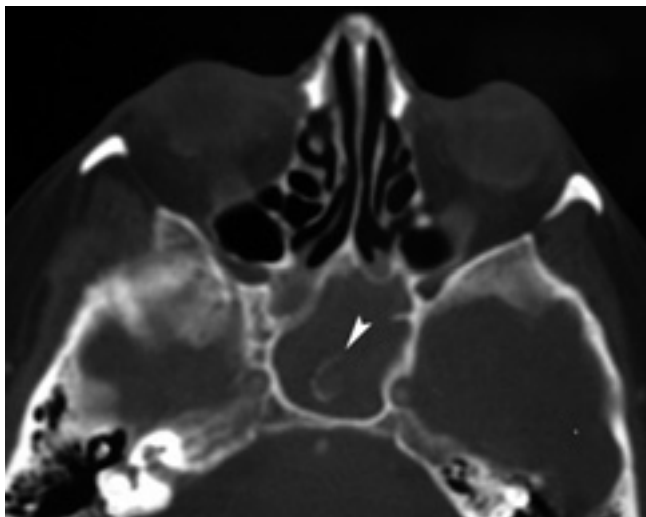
First case. Axial CT-scan realized after intravenous antibiotic therapy. There is a bilateral sphenoiditis and numerous calcium opacities within it (white arrow), demonstration of the fungal origin.
